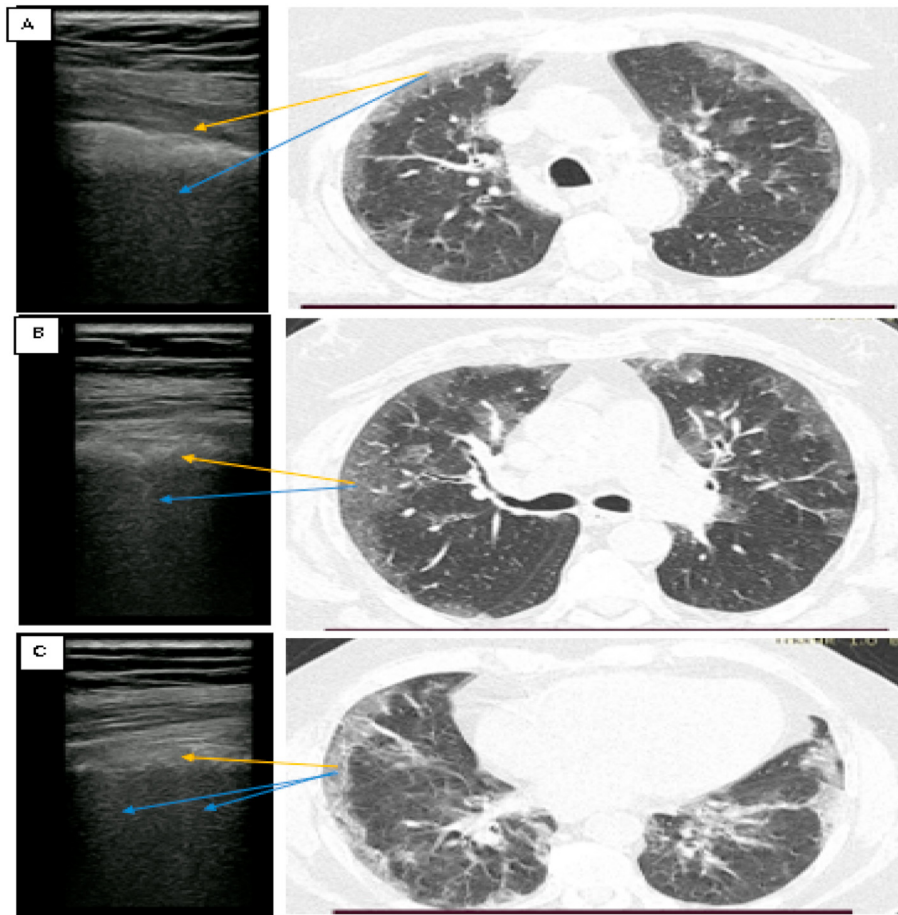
Comparative LUS and CT in COVID-19 patients. Yellow arrow = pleural line with irregularities and discontinuity (A), subpleural consolidation (B, C). Blue arrow = multiple B-lines with coalescence tendency. (For interpretation of the references to colour in this figure legend, the reader is referred to the Web version of this article.)
